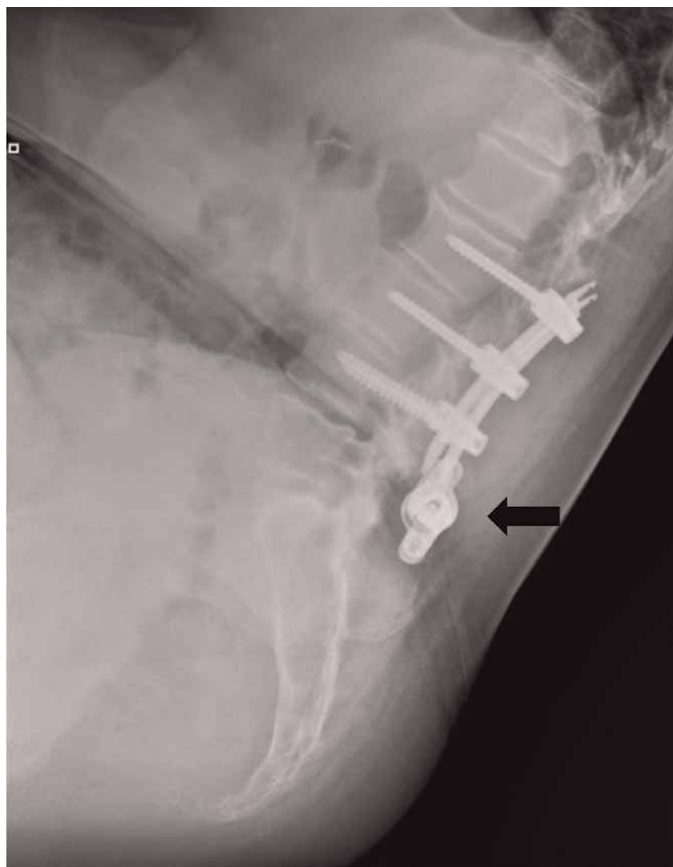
Adjacent segment disease (ASD). Lateral x-ray film at 2-year post-ISD implant: pedicular fixation L2-L3-L4 is seen; the spacer at the caudal ASD level is well inserted between the spinous processes (black arrow).
